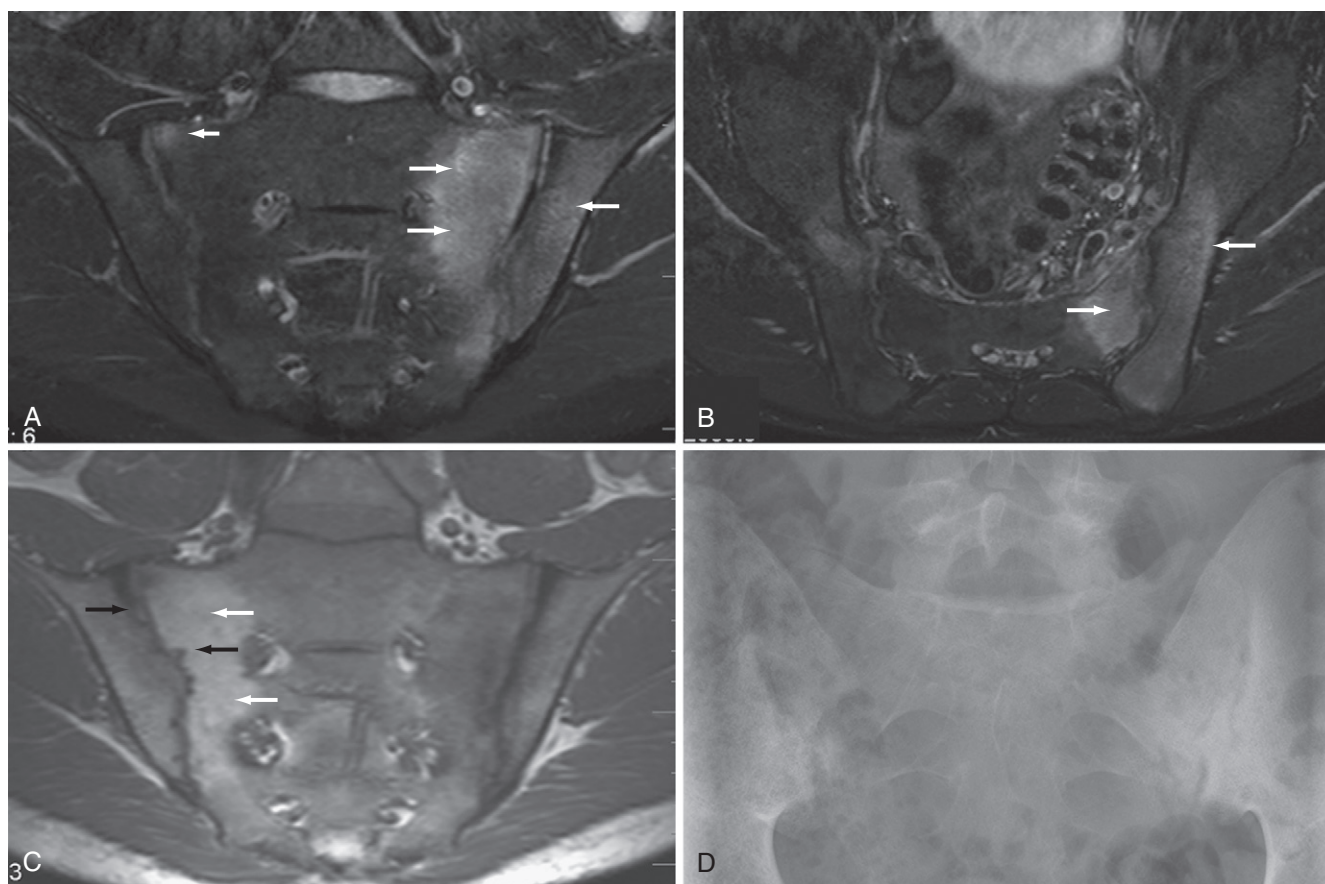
Sacroiliitis in spondyloarthritis (magnetic resonance imaging [MRI] and x-ray). MRI (A through C) and x-ray (D) of the sacroiliac joints of a 26-year-old male with inflammatory back pain for 4 years. Semi-coronal (A) and semi-axial (B) short tau inversion recovery images show massive iliac and sacral bone edema around the left sacroiliac joint (i.e., demonstrate severe active sacroiliitis) (long arrows in A and B). Inflammation (sacroiliitis) is also present in the right sacroiliac joint (short arrow in A). T1-weighted semi-coronal image shows fat infiltration (white arrows in C) and bone erosion (black arrows in C). Anteroposterior radiograph (D) shows bilateral mild sclerosis on the iliac side, and bilaterally the articular surface is less well defined than normal, consistent with erosion. However, this feature is exaggerated by overlying bowel gas. (Courtesy Susanne Juhl Pedersen, Glostrup, Denmark.)
